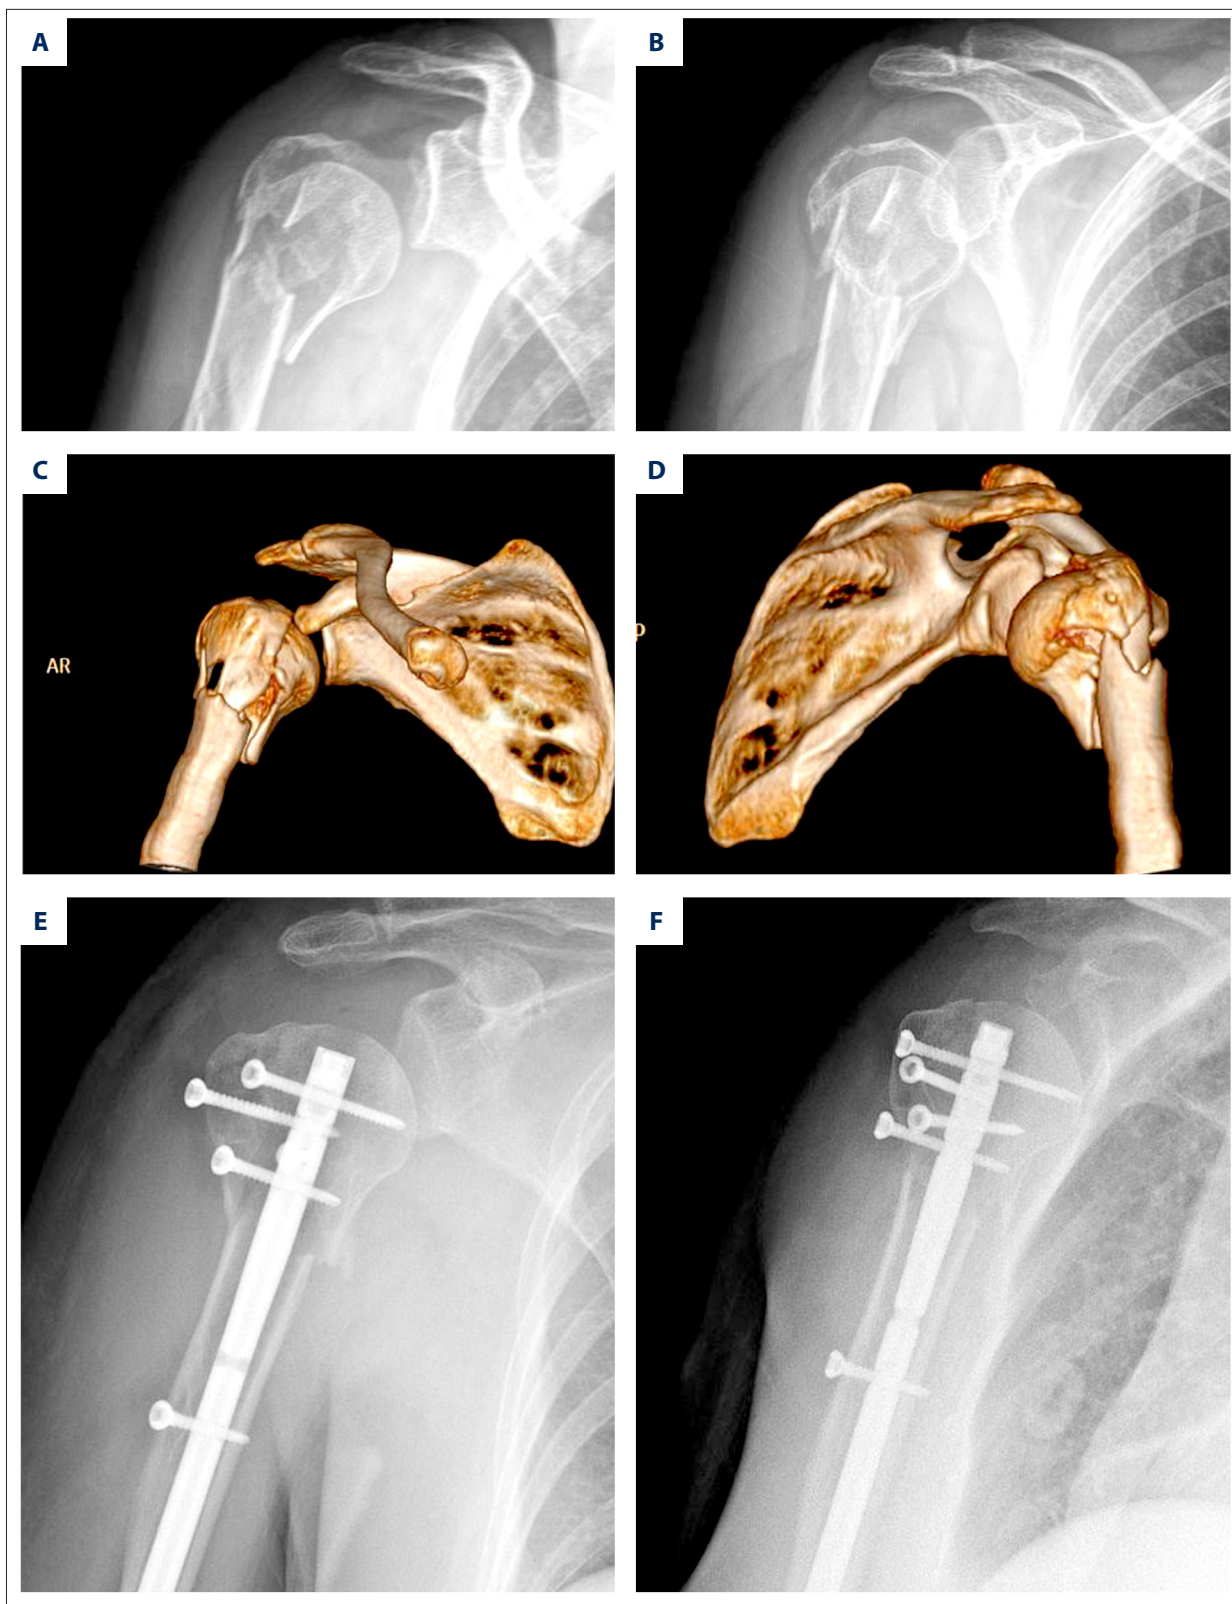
Imaging data for a Neer type IV fracture. (A, B) Preoperative X-ray images; (C, D) preoperative computed tomography images; (E, F) postoperative X-ray images.
